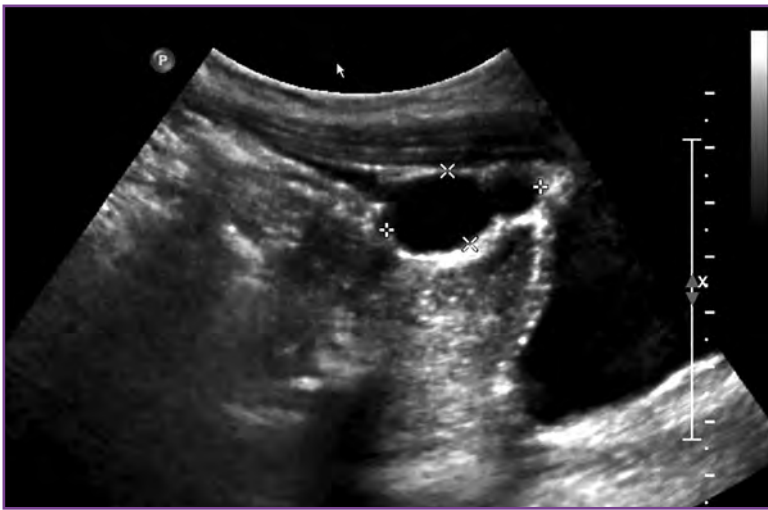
A 2-cm left ovarian cyst identified at ultrasonography of the bladder.
